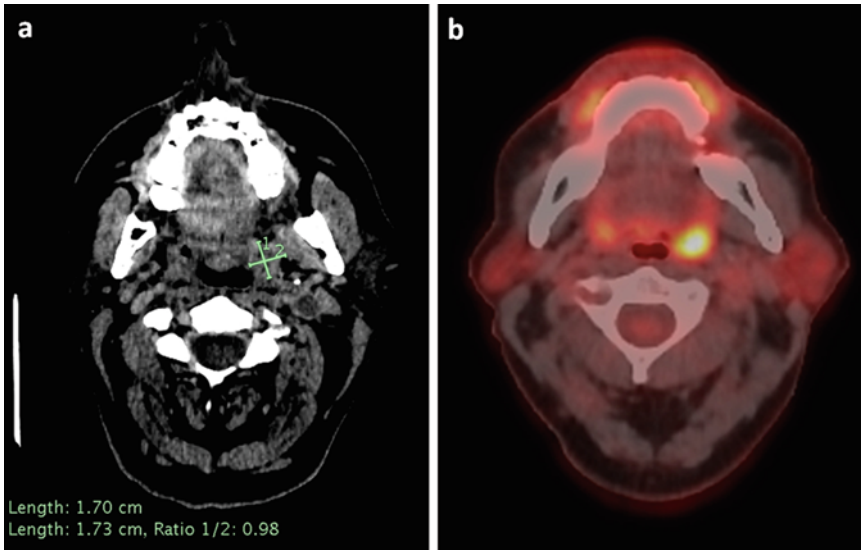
T1N2b squamous cell carcinoma of the palatine tonsil. CT (a) shows a heterogeneously enhancing centrally necrotic mass within the superior aspect of the left palatine tonsil, measuring up to 17 mm consistent with a left tonsillar SCC. Multiple centrally necrotic/cystic left
